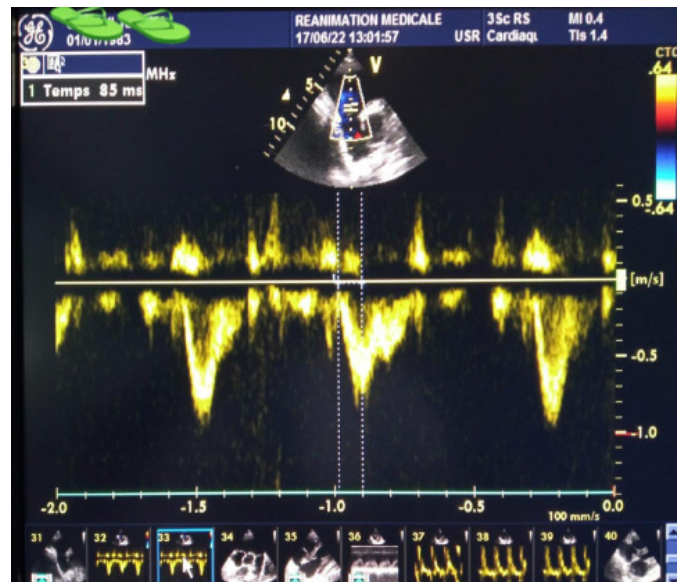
Pulsed doppler, a collapsed TAC and a Notch aspect.
